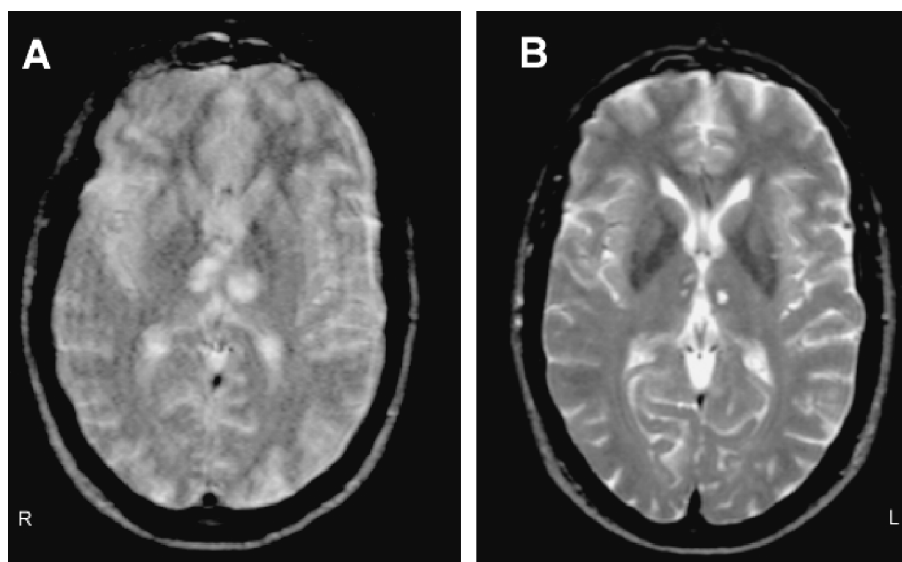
Axial T2-weighted MRI showing bilateral thalamic infarction in the paramedian thalamosubthalamic territory on day 3 post-stroke (A) and at 6 months post-stroke (B).
